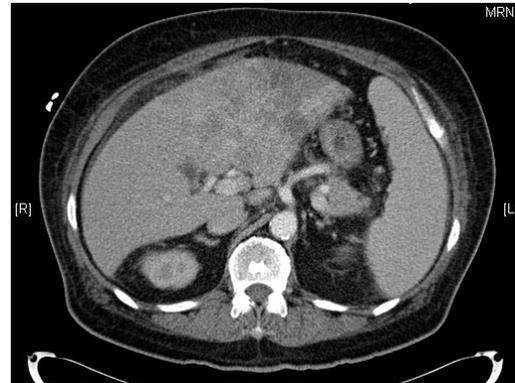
CT Abdomen/Pelvis with IV contrast demonstrate a heterogenous infiltrative mass replacing the left hepatic lobe with smaller ill-defined lesions in the right lobe. Ascites and splenomegaly also noted.
